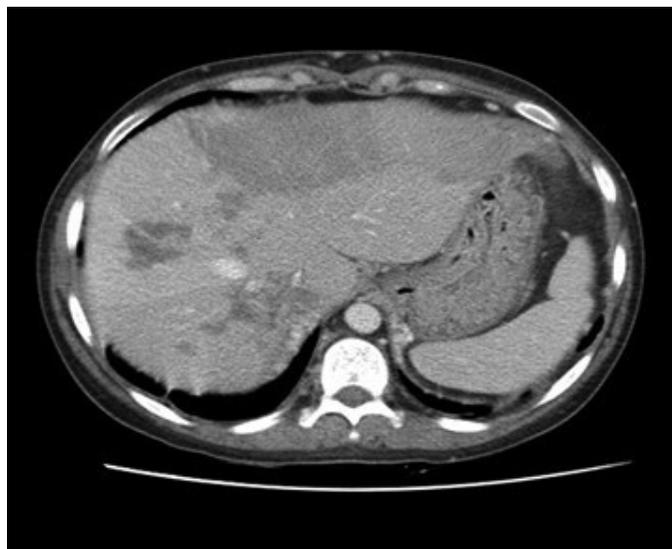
Widespread hypoechoic lesions detected by abdominal CT imaging
